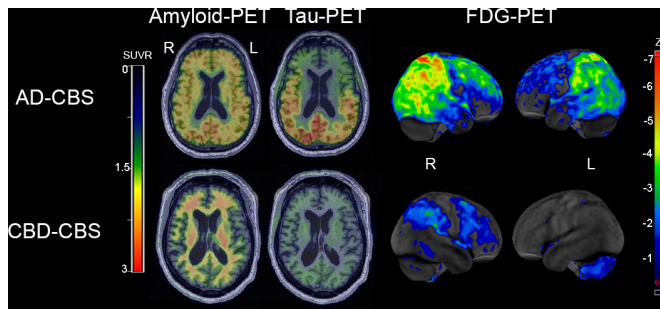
Representative amyloid PET with $[^{11}\text{C}]\text{PiB}$, tau PET with $[^{18}\text{F}]\text{flortaucipir}$ and glucose PET with $[^{18}\text{F}]\text{fluoro-2-deoxyglucose}$ (FDG) in AD-CBS and CBD-CBS. The amyloid PET and tau PET are shown on representative axial slices on the same colour scale, while the FDG-PET highlights regional metabolism with z-scores between -1 and -7 SD from controls using CortexID suite software. Upper images are from a patient with AD-CBS. Amyloid PET shows diffuse ligand uptake in cortical grey matter, and tau PET reveals increased signal in the temporo-parieto-occipital lobes. FDG-PET reveals hypometabolism in bilateral parietal cortex extending into occipital lobes (right >left) and right >left superior frontal cortex. Lower images are from a patient with CBD-CBS. There is no evidence of increase amyloid PET uptake in the cortical grey matter and there is no increase tau PET uptake. FDG-PET reveals mild hypometabolism in the right premotor cortex and postcentral gyrus in CBD-CBS. AD-CBS, Alzheimer's disease presenting as corticobasal syndrome; CBD-CBS, corticobasal degeneration presenting as corticobasal syndrome; FDG, fluorodeoxyglucose; L, left; PET, positron emission tomography; PiB, Pittsburgh compound-B; R, right; SUVR, standardised uptake value ratio.
